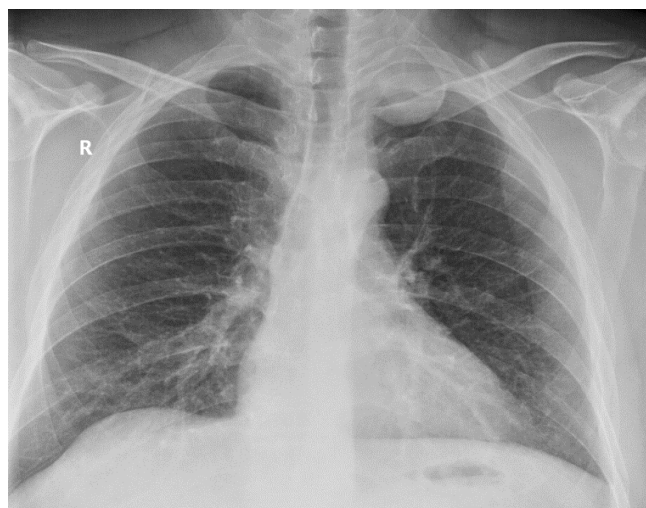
A mass in the left apex identified on chest X-ray
